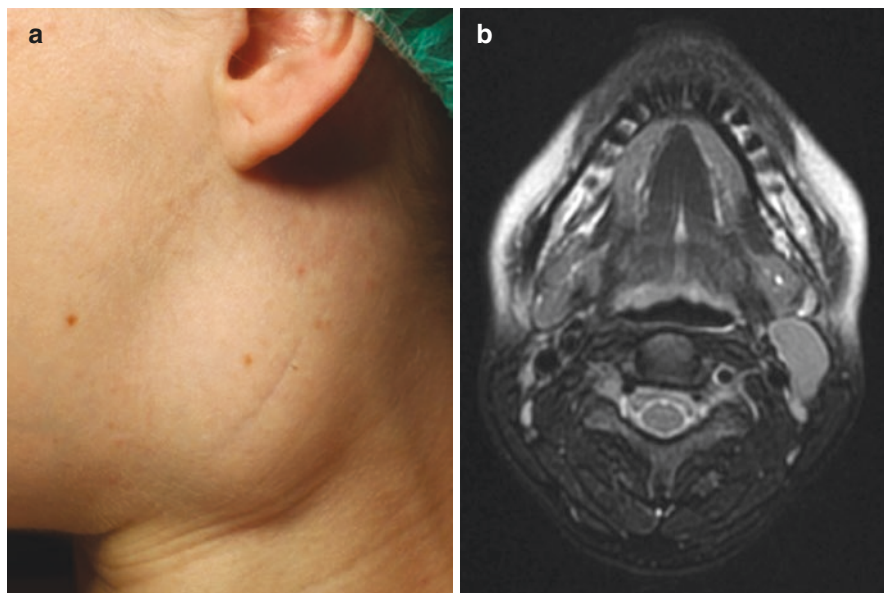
Clinical picture of a pregnant patient with a branchial cleft cyst on the left side of the neck (a) and the corresponding MRI showing the cystic mass in the vessel/nerve sheath (b) by Raguse JD, Anagnostopoulos I, Doll C, Heiland M, Jöhrens K. Possible Estrogen Dependency in the Pathogenesis of Branchial Cleft Cysts. *Biomed Res Int.* 2017;1,807,056. (Creative Commons CC-BY license at <https://doi.org/10.1155%2F2017%2F1807056>)
